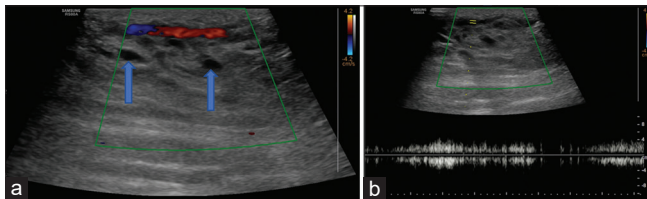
Ultrasound images showing (a) a vessel (red and blue color flow) is seen traversing between the lymphatic channels (blue arrows) in the anterior abdominal wall in the subcutaneous plane, (b) spectral Doppler confirmed it to be a vein, having a monophasic flow
